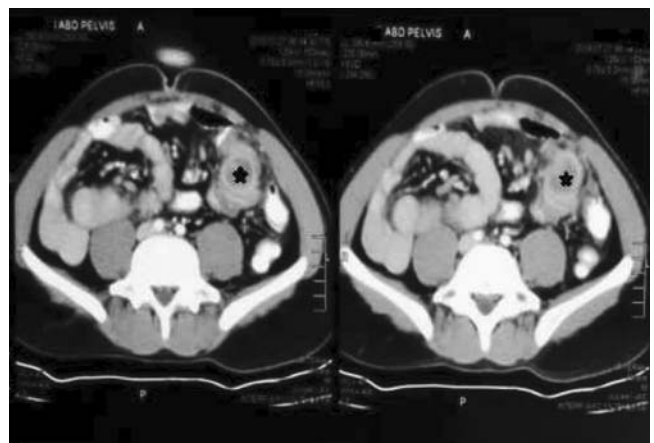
CT Scan of the abdomen. Asterisk: Inflammatory mass with fat stranding on the left half.
